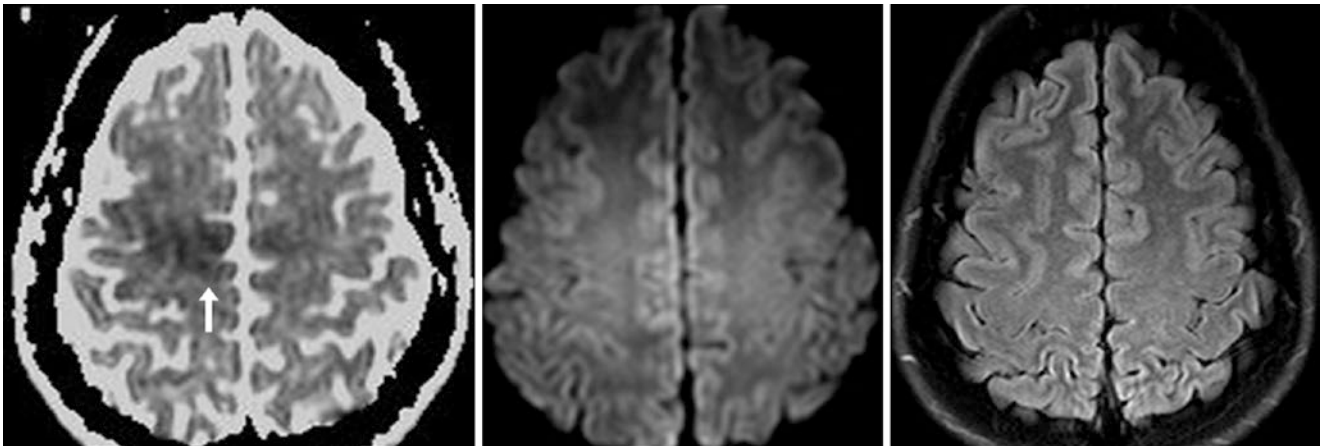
In a 33-year-old, a focal region of dark artifact was likely due to eddy currents with Lorentz forces (*arrows*), as shown on an ADC map at 3 T (*left*). The region appears normal on DWI (*middle*) and FLAIR images (*right*)
